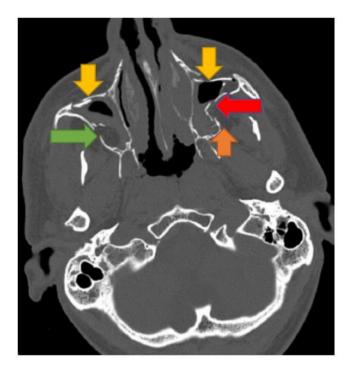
First patient non-enhanced brain computed tomography (NECT) after trauma revealing multiple skull and facial fractures; arrows indicating maxillary cavity fractures (bone window), October 2023.
